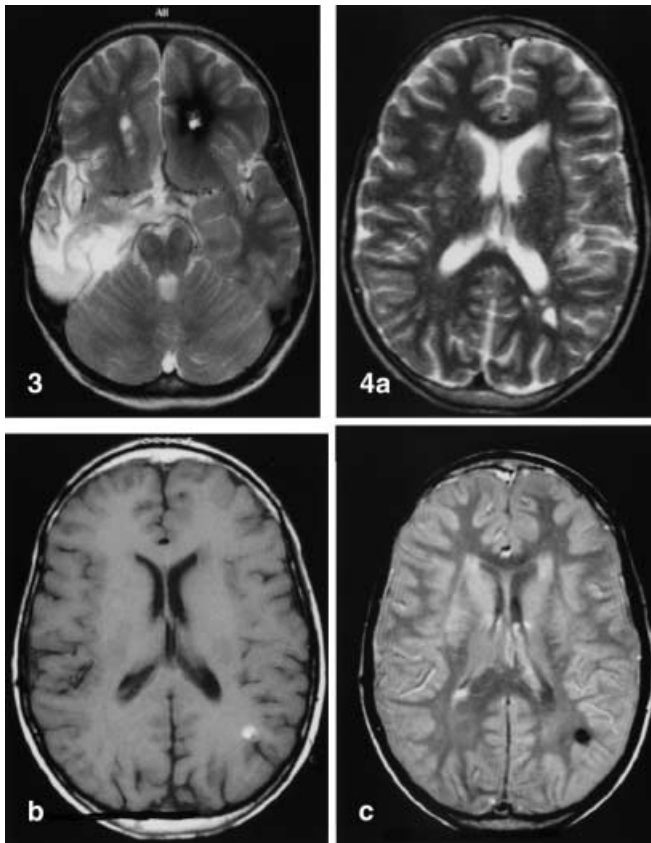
Hemorrhagic lesion. T2-weighted image reveals a large deposition of hemosiderin similar to cavernoma of the left frontal lobe and a cystic nonhemorrhagic lesion of the right frontal lobe in a 13-year-old boy 9 years after therapy of a malignant oligodendroglioma. Postoperative defects and gliosis of the right temporal lobe are normal postoperative findings
